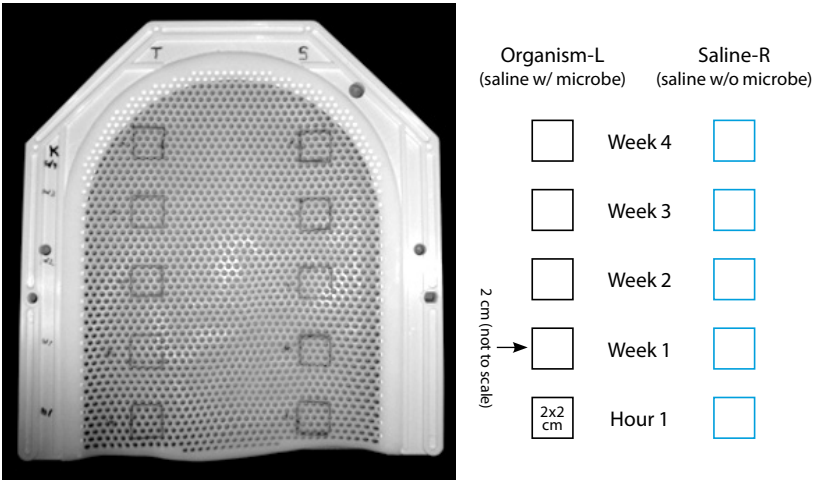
Mask sample squares template. Thermoplastic mask with template-sketched 2 cm × 2 cm squares indicating inoculation areas on left. Radiographic film marking template layout with corresponding sampling areas indicated on right. Images courtesy of the authors.
